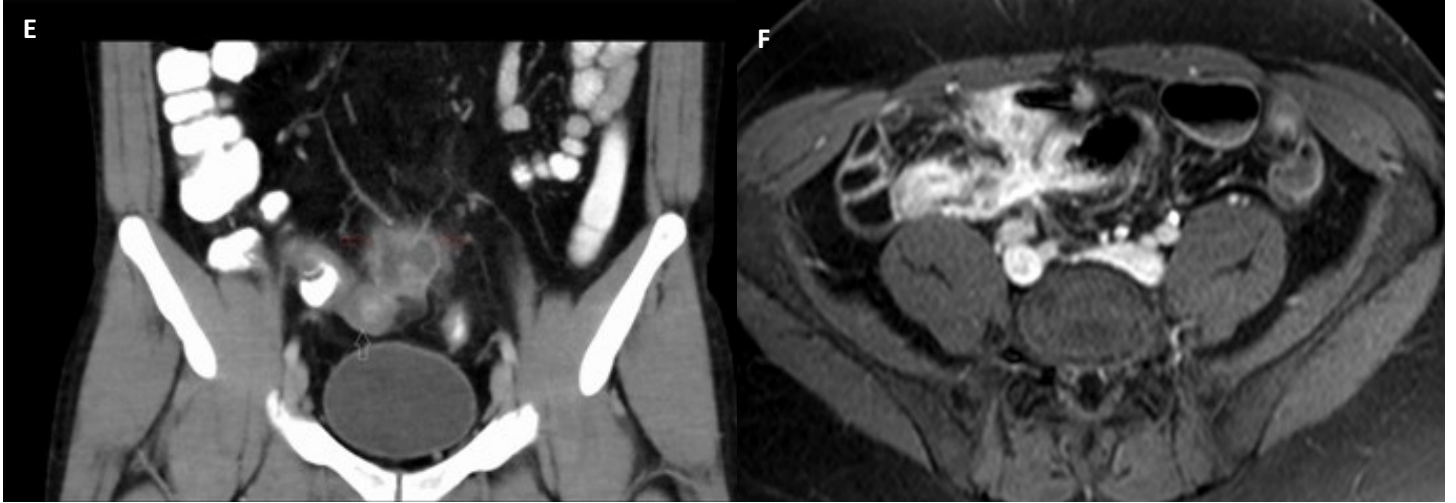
E – Contrast-enhanced CT of the abdomen, coronal plane, portal phase, positive peroral contrast. Thickening and edema of terminal ileum with swelling of adjacent fat and adjacent abscess (fluid collection with enhancing rim and swelling of adjacent fat) – image of active inflammation of Crohn’s disease complicated by abscess.
